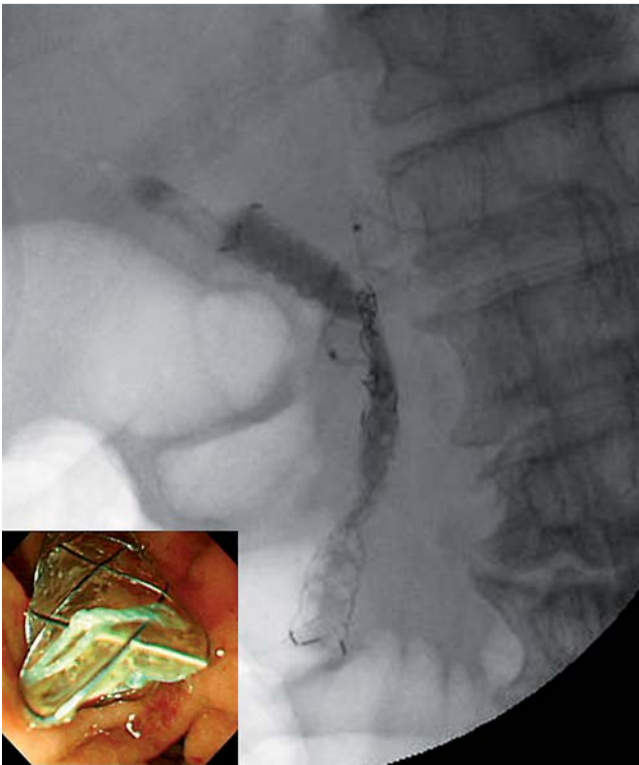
Radiograph showing the arterio-biliary fistula successfully sealed using the fully covered self-expandable metallic stent (inset: endoscopic view of the stent passing through the ampulla of Vater to the duodenum).
